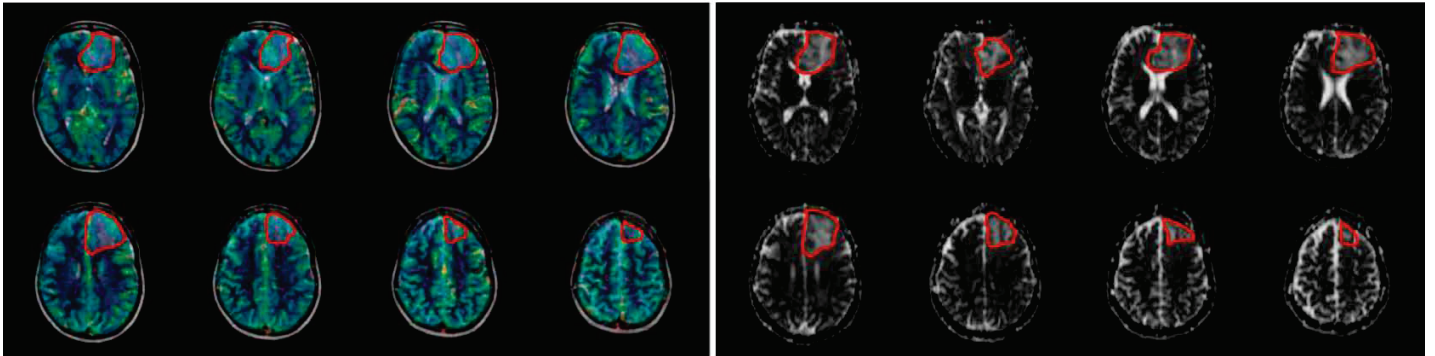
Segmentation of diffuse gliomas for studies I and II. A series of ROIs were manually drawn on every representative image slice for the entire tumor volume on ADC maps and T2-weighted images.
